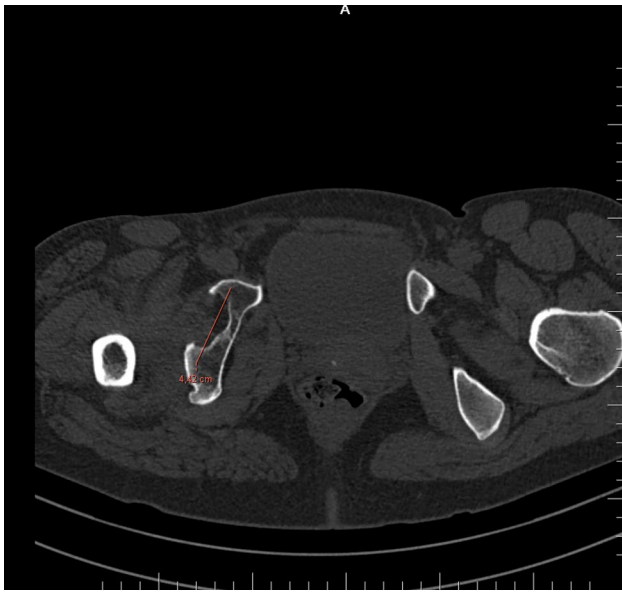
Axial CT slice showing true acetabulum
